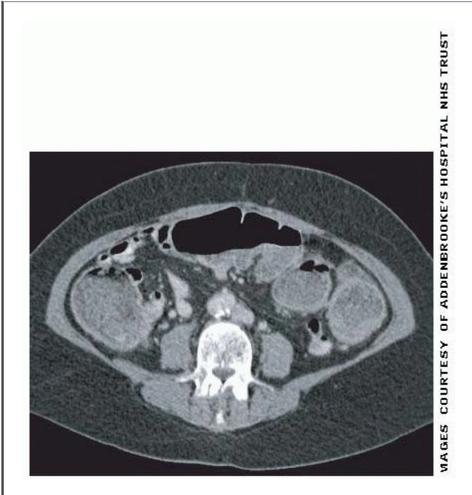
Axial CT of the abdomen post IV contrast medium showing dilated loops of fluid and air filled large bowel. The cause or level of obstruction is not discernable from this image. A 'transition zone' from dilated to non-dilated bowel may be present at the point of obstruction.
